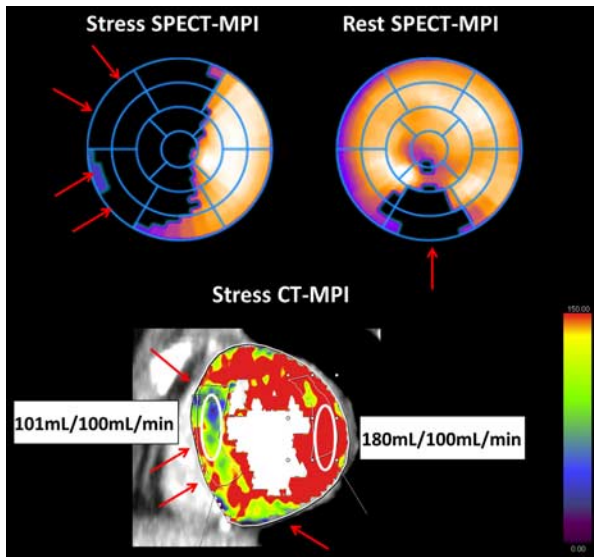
Example of concordant findings on CT-MPI and SPECT-MPI. Images of a 56-year-old woman with known CAD. The attenuation-corrected SPECT images show a reversible defect in the anterior and septal walls on the stress SPECT images and a small fixed defect in the inferior wall on the rest SPECT images (red arrows). This reversible defect is reflected by a decreased MBF (red arrows) in the CT-MPI images (101 vs. 180 mL/100mL/min) measured by ROIs (white circles).
